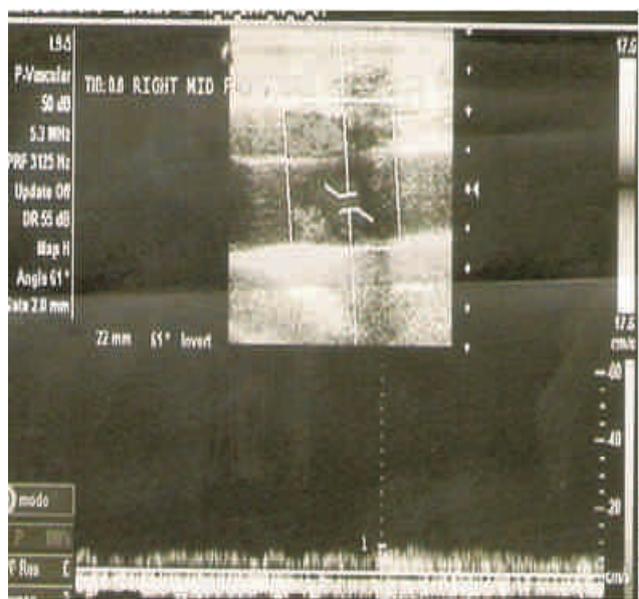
Intravascular plaque demonstrated by Doppler Scanning
